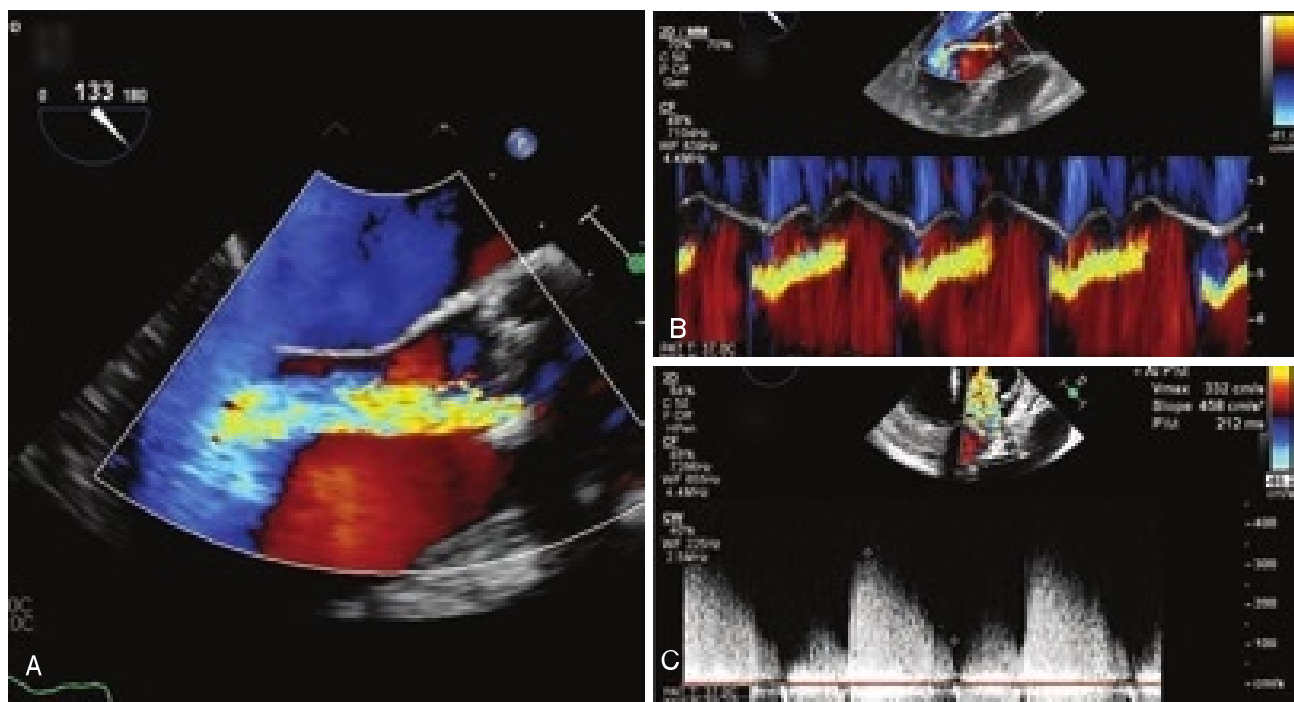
Transesophageal echocardiography images of a patient with aortic regurgitation showing (A) regurgitant flow into the left ventricular outflow tract (LVOT) during diastole, (B) M-mode placed in the LVOT during diastole allowing measurement of the regurgitant jet width as a percentage of overall LV outflow tract width (Perry index), and (C) pressure half-time measurement obtained in the deep transgastric window.
